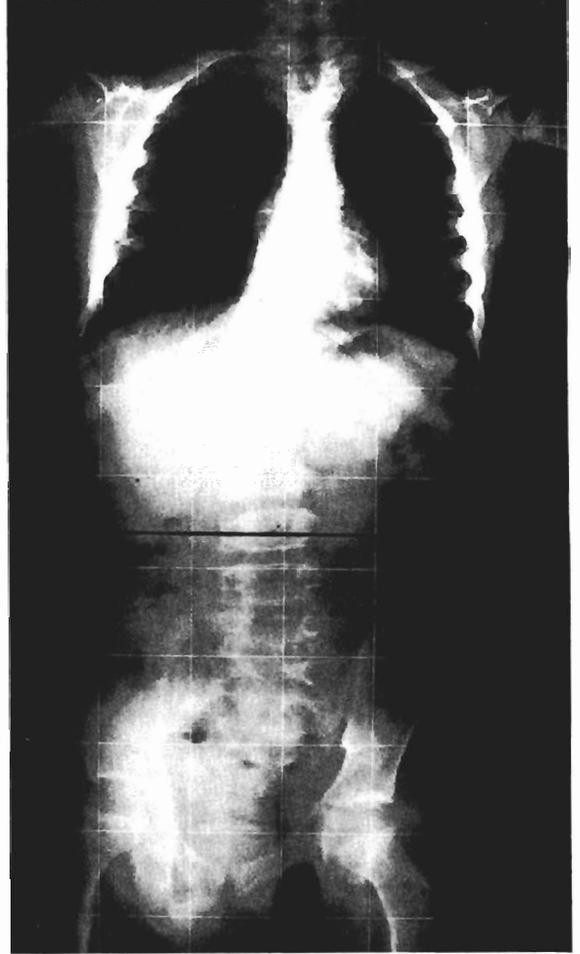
At the age of 3 years this boy suffered a complete and permanent paraplegia owing to a fracture dislocation at T12–L1. This radiograph at age 6 years shows a scoliosis and an interesting head-within-a-head appearance of the femoral heads, representing disuse atrophy followed by activity. A Harrington fusion was carried out at the age of 7 years, which must be repeated because of pseudoarthrosis. He has also had release surgery for leg contractures. He is mostly in a wheelchair at the age of 16 years.
